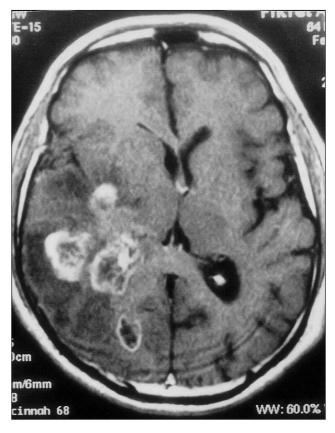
The axial MRI scan of patient 1 showing synchronous multiple contrast-enhancing mass lesions located in the right hemisphere.
